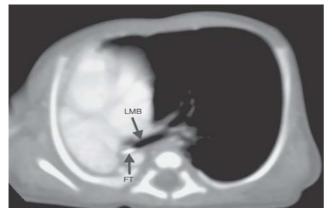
Computed tomography of the chest showing probable tracheo-esophageal fistula. The area between mid oesophagus and adjacent left main bronchus are not visualised well.
